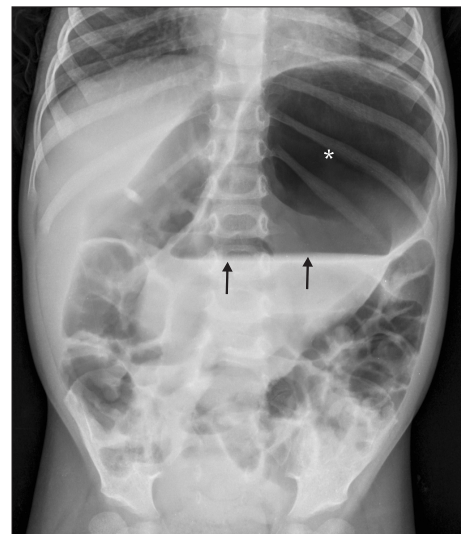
Upright plain abdominal radiograph showing markedly dilated bowel loops with clear-cut air-fluid levels in the reported patient. Notably, a massive gastric dilatation (*) with fluid stagnation (arrows) is clearly detectable.
